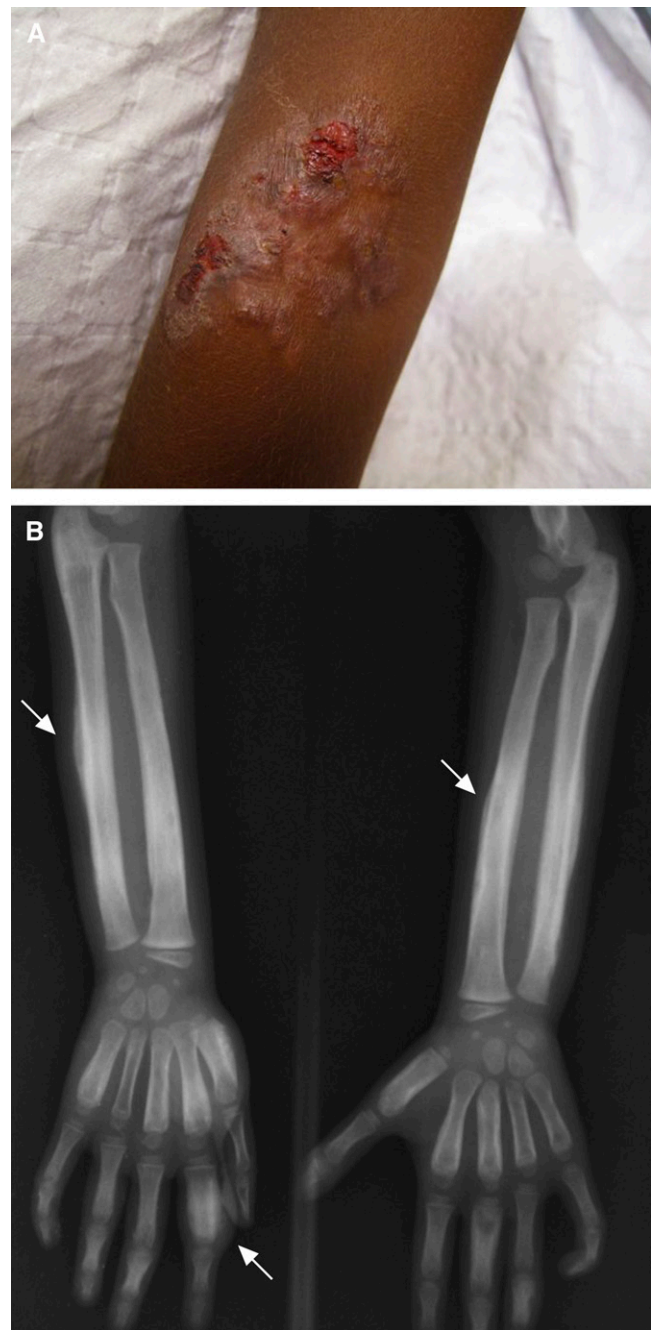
Secondary skin lesion (crustopapillomatous) on the left arm of a patient with yaws (A) and radiograph of her forearms and hands (B), Papua New Guinea. Arrows show dactylitis with thickening of the cortex and increase in width of the phalanx and bilateral periosteal reaction of the ulna and radius with widespread onion layering deposition of periosteal bone.
